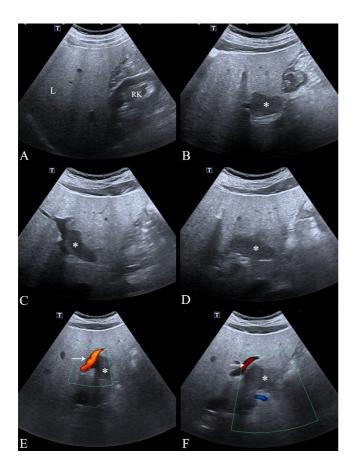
CASE 1. Ultrasound (US) liver images performed after the initial CT scan. A – Hyperechoic liver parenchyma (L) compared to hypoechoic right renal cortex (RK) and decreased posterior attenuation of the liver, both suggesting diffuse hepatic steatosis. B, C, D – different imaging planes showing a hypoechoic fat sparing area (*) located within the $\mathrm{III}^{\mathrm{rd}}$ segment. E, F – Doppler images showing no vascularization of the (pseudo)lesion (*) and no other vascular communication with the left branch of the portal vein (arrows).
